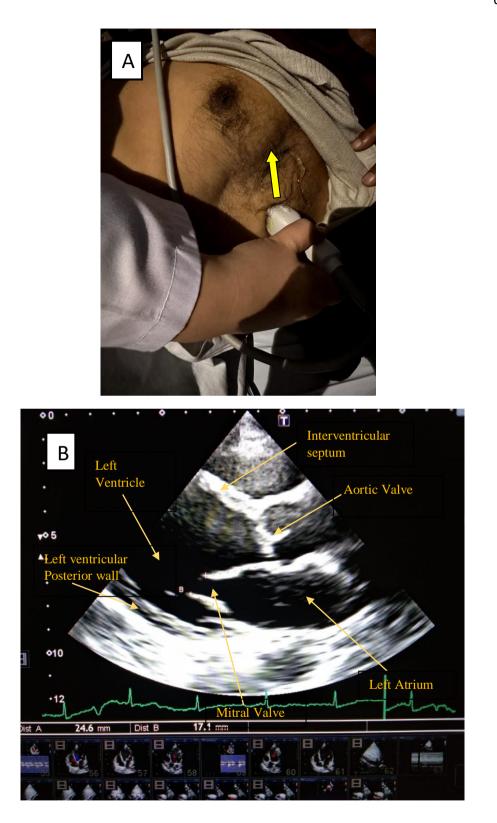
(A) Transducer position for parasternal long-axis view. (B) Echocardiographic image for a parasternal long-axis view from the current study conducted at NICVD, Karachi.
